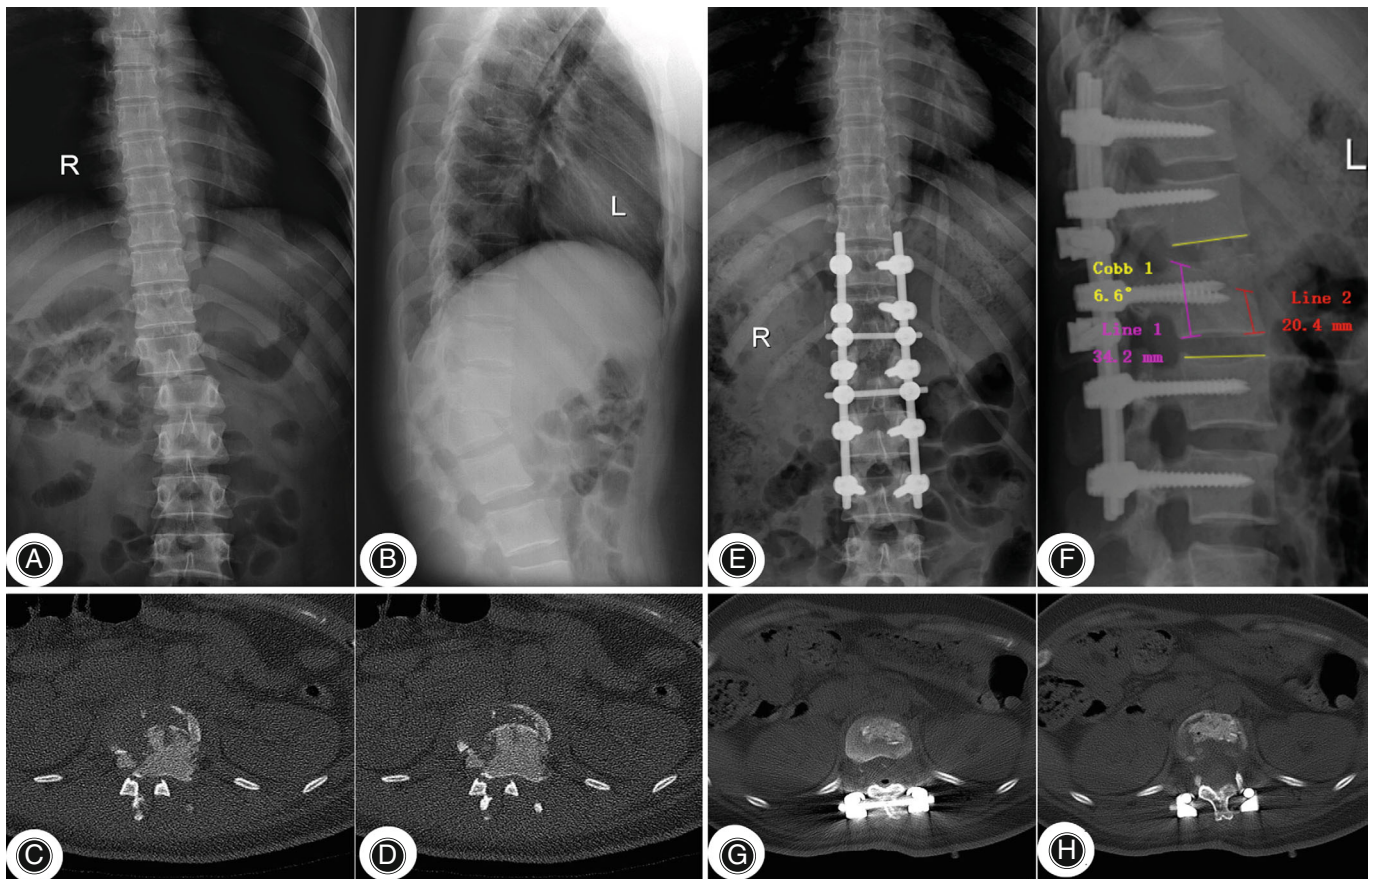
A 23-year-old female suffered from lumbar 1 and 2 vertebral burst fracture combined with fracture and dislocation injury with TLICS score of 9 points (Cobb angle: 6.6°, Anterior vertebral losing height of fractured vertebra = line 2/line 1 = 0.60). Preoperative imaging examinations of anteroposterior and lateral (A, B) radiographs, CT (C, D) showed that vertebral burst fracture resulted in spinal stenosis due to intruding of the fracture block into the spinal canal. The patients were followed up for 4 years after posterior lumbar 1 and 2 vertebral fractures were decompressed by translaminar window and intervertebral fusion with bone graft. Anteroposterior and lateral radiographs (E, F), CT (G, H) were reviewed, the results showed no compression of the spinal canal and bone graft tamping in the vertebral body was satisfactory. TLICS, thoracolumbar injury classification and severity score; CT, computerized tomography.
